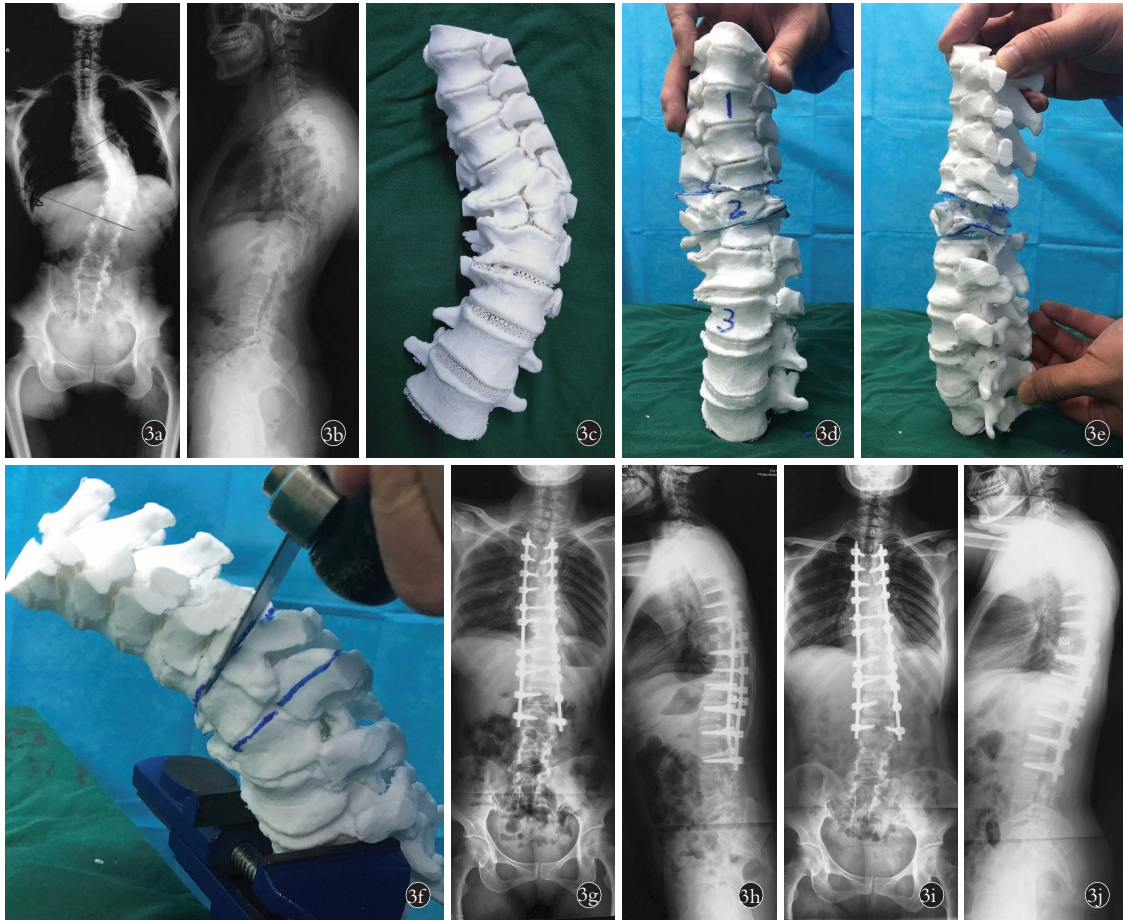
女性患者,41 岁,因“自幼脊柱畸形伴胸背部疼痛不适 30 余年”入院。诊断:先天性脊柱侧后凸畸形 3a,3b。术前站立位全脊柱正侧位 X 线片,胸椎最大侧凸 Cobb 角为 49°,最大后凸 Cobb 角为 70° 3c,3d,3e,3f。术前规划截骨矫形术。通过颈椎三维 CT 打印出 1:1 畸形的脊柱模型,仔细观察模型形态,与影像学对比,并进行术前手术模拟。即行后路切开胸腰椎截骨矫形融合内固定术,术中见后凸畸形部位、形态及其与周围结构解剖关系与打印模型一致,按照术前模拟操作快速行椎弓根螺钉置入及截骨矫形手术,并予以植骨融合钉棒内固定 3g,3h。术后 1 个月站立位全脊柱正侧位 X 线片,胸椎最大侧凸 Cobb 角矫正到术后 7°,最大后凸 Cobb 角矫正到术后 30° 3i,3j。术后 1.5 年站立位全脊柱正侧位 X 线片,胸椎最大侧凸 Cobb 角为 8°,最大后凸 Cobb 角为 36°
